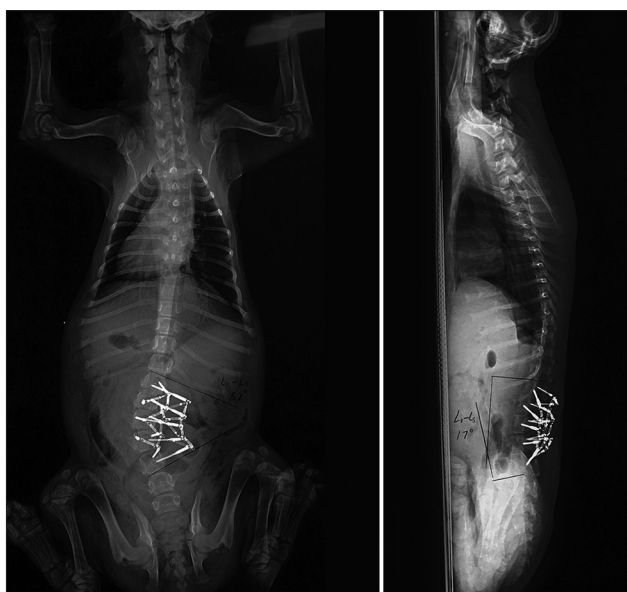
Posteroanterior and lateral radiographs of the spine 7 weeks after surgery.
